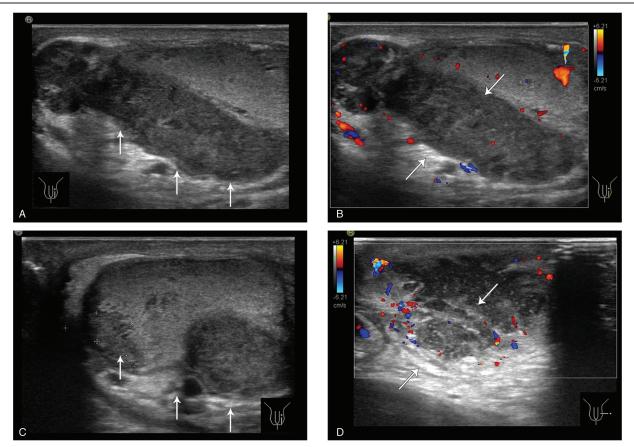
Ultrasonographic appearance of the epididymis in tuberculosis of the male genital system. (A) The left epididymis of a male 56-year-old male genital tuberculosis patient was visualized (white arrow). (B) The left epididymis blood signal was abundant (white arrow). (C) The enlarged epididymis behind the left inhomogeneous testicle was indicated by the white arrow. (D) The abscess in the left scrotal wall was indicated by the white arrow.
